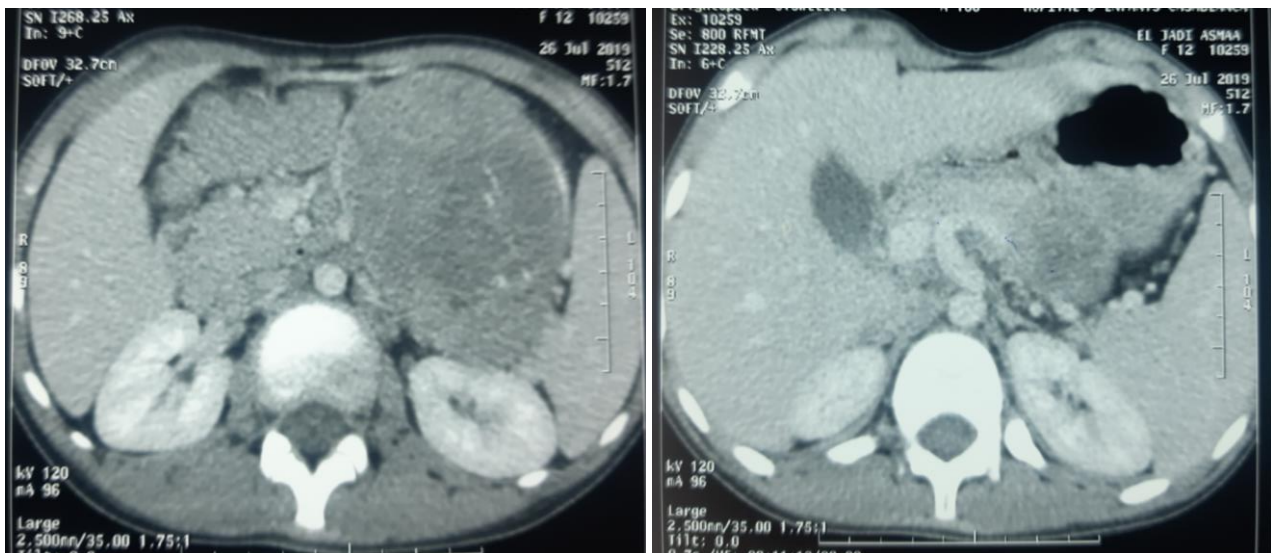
Initial Abdominal CT scan: a well-defined mass in the body and head of the pancreas.
